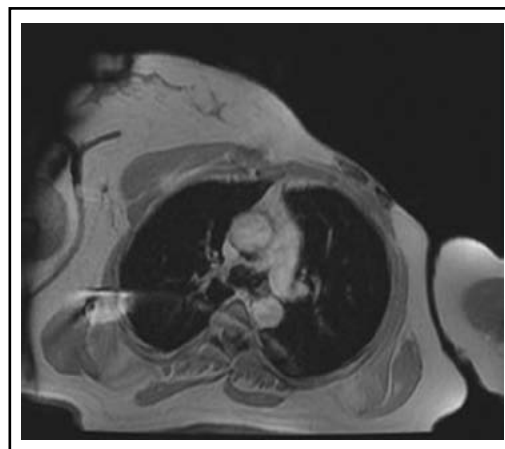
The MRI taken 3 months after the end of the HBOT treatment showed that the infection in the ribs was totally cured.
